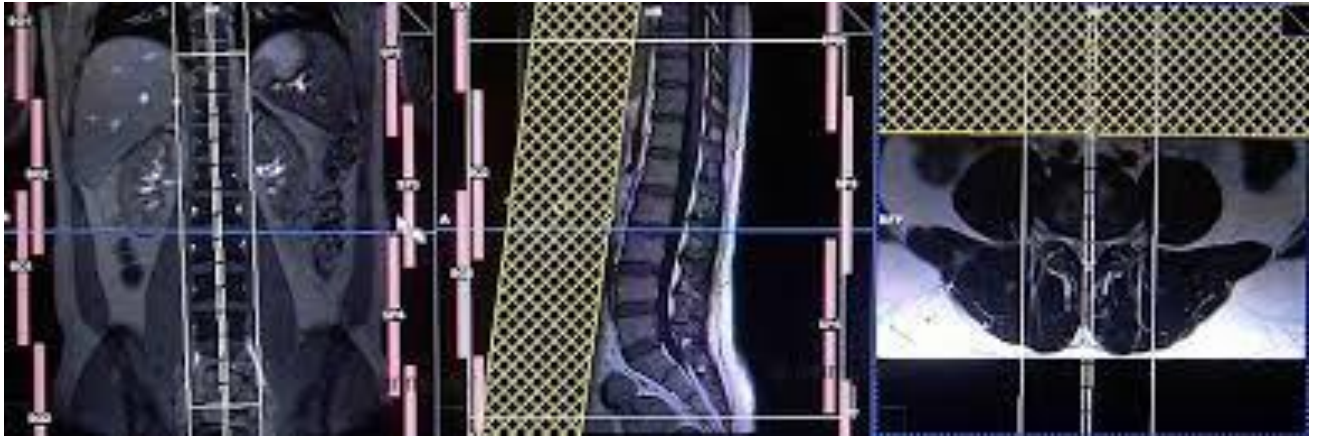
Planning and protocol sagittal MRI scan of lumbar spine
